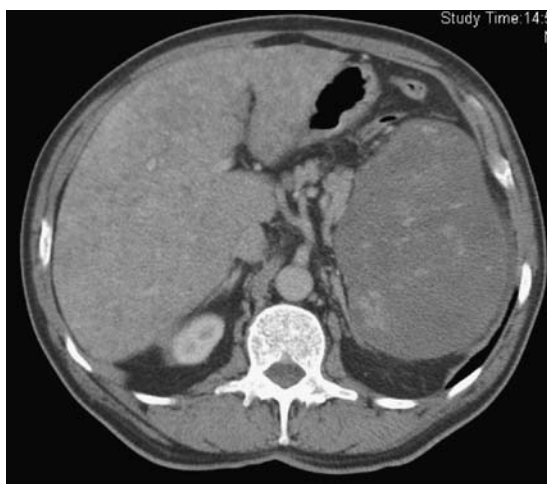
CT scan showing enlargement of liver and spleen, with a heterogenous parenchymal appearance in both organs.
